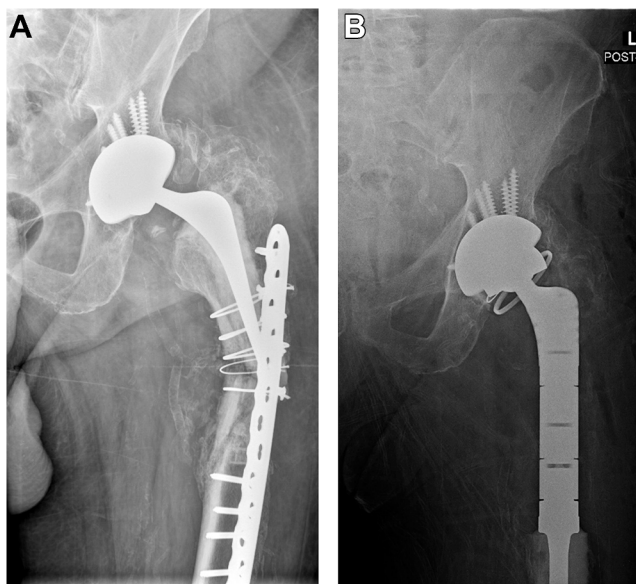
Radiographs showing (A) a periprosthetic fracture resulting in femoral bone loss (Paprosky IV) in a 97-year-old man (B) who then underwent a cemented proximal femoral replacement with a constrained liner.
